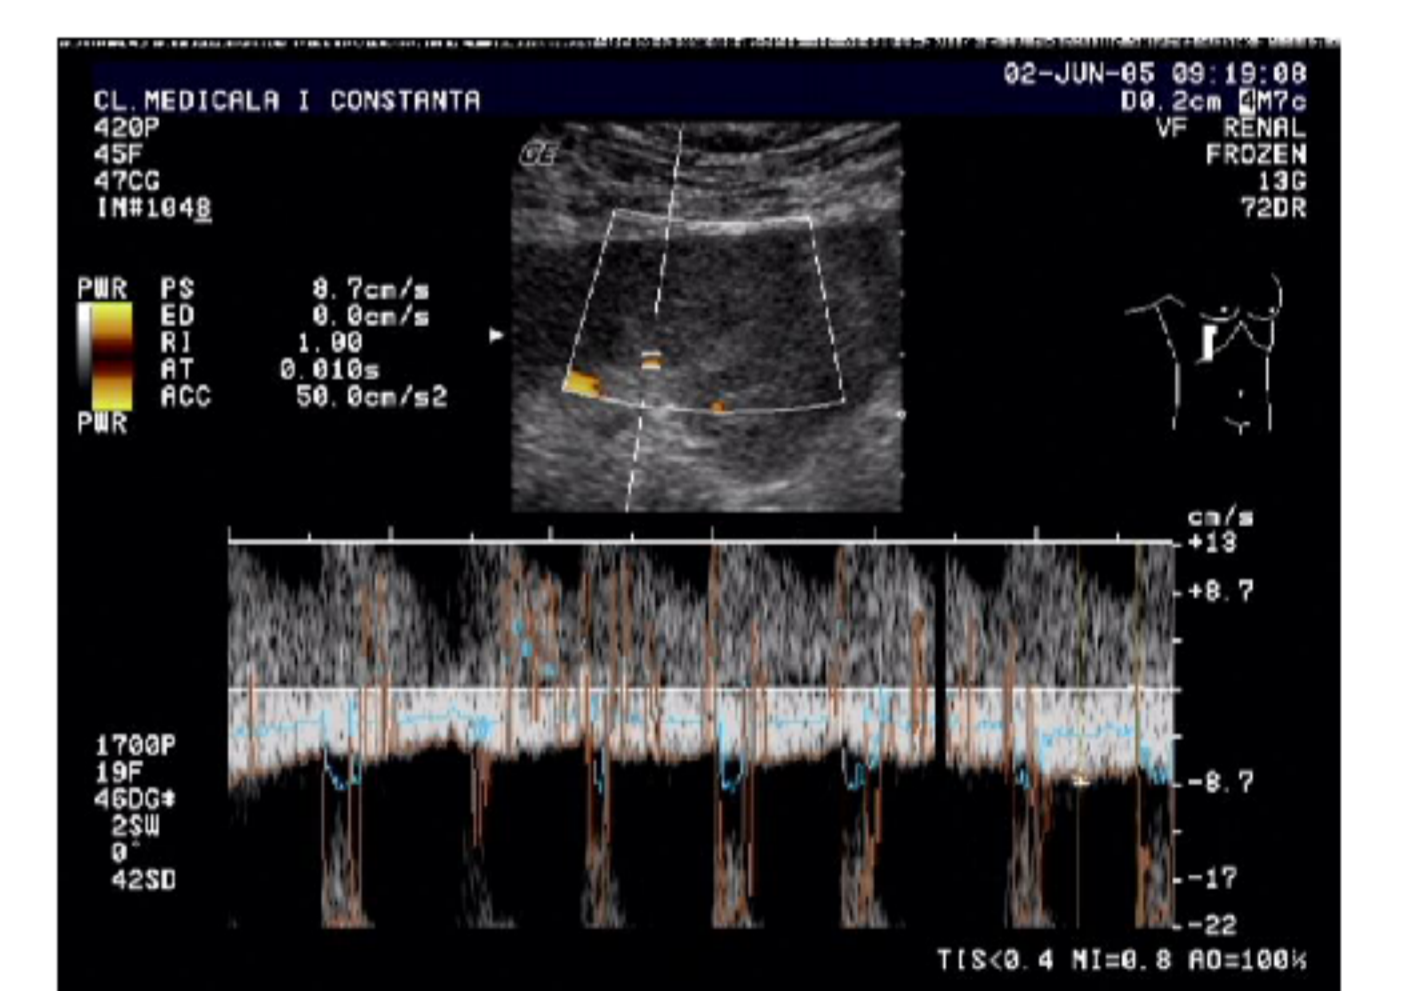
ECHO DUPLEX PULSE WAVE DOPPLER IMAGE WITH AN ARCUATE ARTERY
